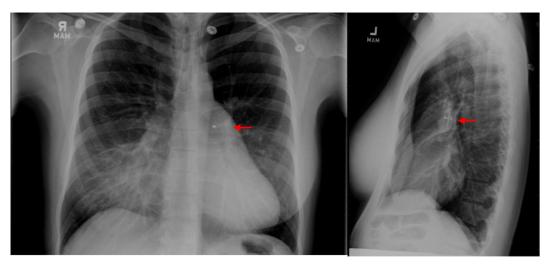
Chest x-ray posteroanterior and lateral views demonstrate the migrated ASDO (arrows) near the left atrial appendage or main pulmonary artery.
